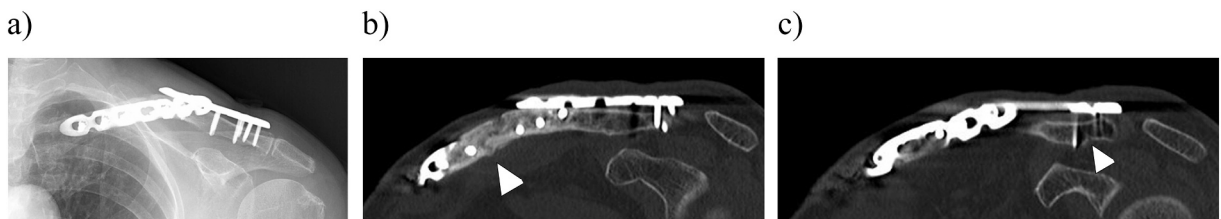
Images obtained 4 months postoperatively; (a) X-ray at 4 months postoperatively; (b), (c) Coronal CT scan images of the bipolar clavicle fracture. Bony fusion was achieved in both medial (b, white arrowhead) and lateral (c, white arrowhead) fracture site.
